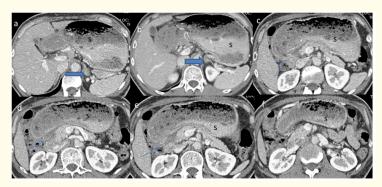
Axial post oral and IV contrast axial images reveal Circumferential antral/first part of duodenal thickening with significant surrounding fat stranding (Thin arrow in image #c, d and e) and upstream gastric dilatation and stagnant gastric content (S in Image a, b, c, d, e and f) as described above with no large appreciable mass. Left adrenal nodule which is stable since last CT likely representing benign adenoma (Thick arrow in Image # a and b).
